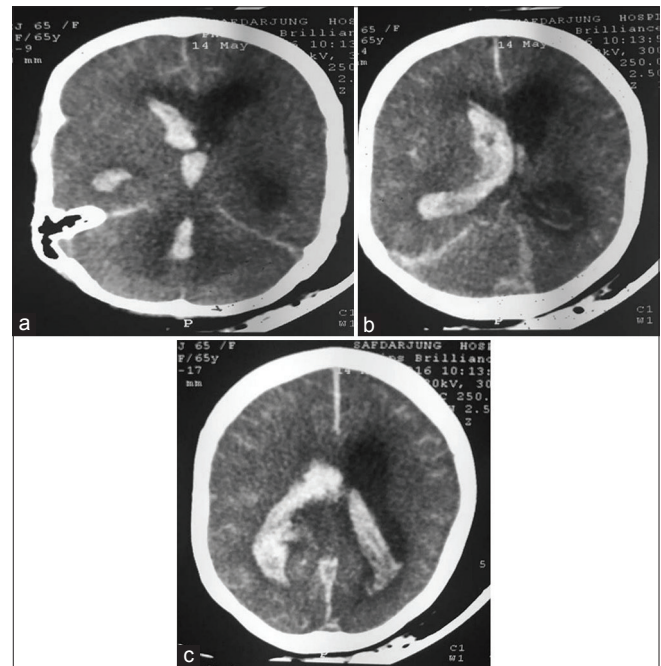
(a-c) Noncontrast computed tomography of head: Dilated bilateral lateral, third, and fourth ventricles showing hyperdense content of blood attenuation suggestive of intraventricular hemorrhage along with linear hyperdensities along bilateral sulcal spaces diffusely and along tentorium cerebelli as well as falx cerebri suggestive of subarachnoid hemorrhage
